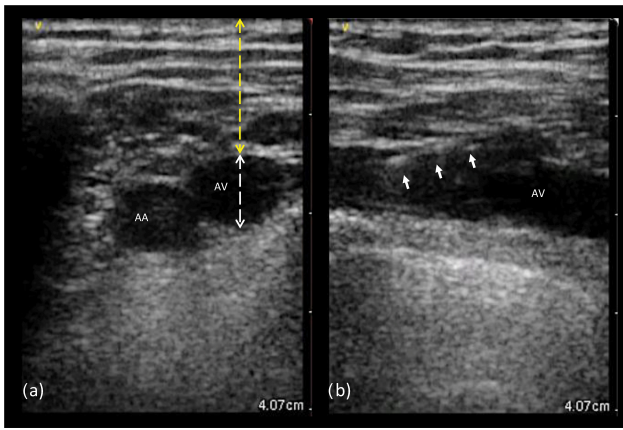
Ultrasound images from left axillary vein. (a) Transverse view: the probe is aligned perpendicular to the axis of both the axillary artery and vein, which appear as anechoic circular images; the anatomic landmarks to measure the axillary vein depth (yellow) and diameter (white) are shown. (b) Longitudinal view: the probe is aligned with the axillary vein course, creating a tubular image of the vessel; the white arrows indicate the guidewire entering the target vein lumen. AA, axillary artery; AV, axillary vein.
